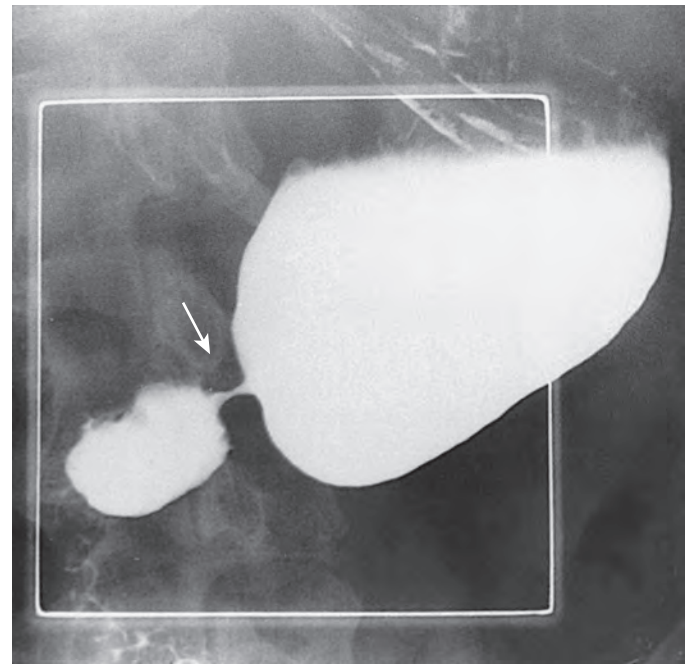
Obstruction at pylorus after pyloroplasty performed during esophagogastrectomy. There is smooth symmetric narrowing of the pylorus (arrow). Obstruction was manifested fluoroscopically by delayed gastric emptying and radiographically by a barium-fluid-air level in the stomach, indicating retained fluid, rather than the normally expected barium-air level. (From Rubesin SE, Beatty SM: *The postoperative esophagus*. *Semin Roentgenol* 39:401–410, 1994.)
